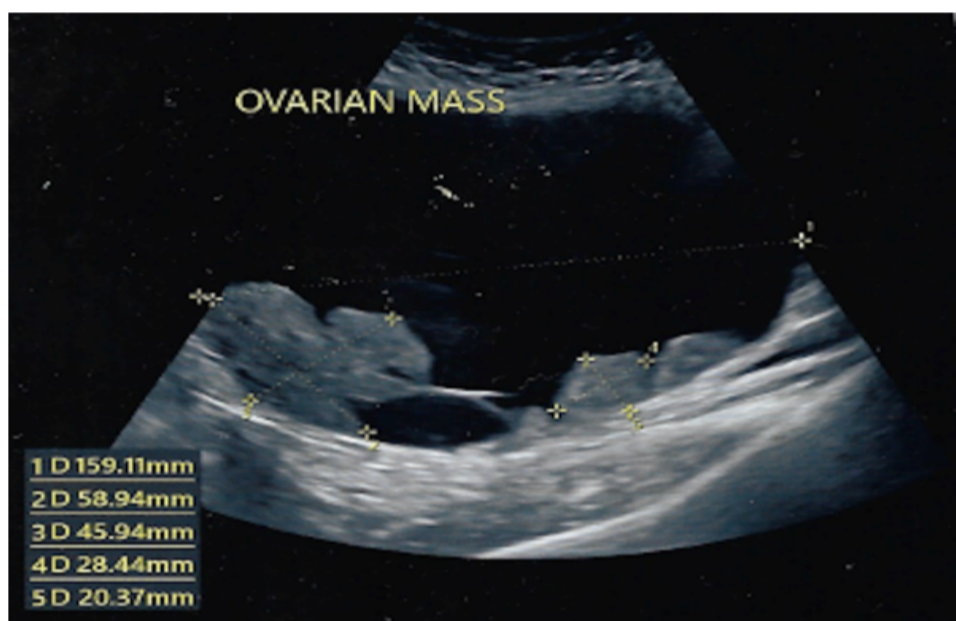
Ultrasound showing well-defined large complex cystic lesion with multiple echogenic nodular solid areas along posterior wall.
